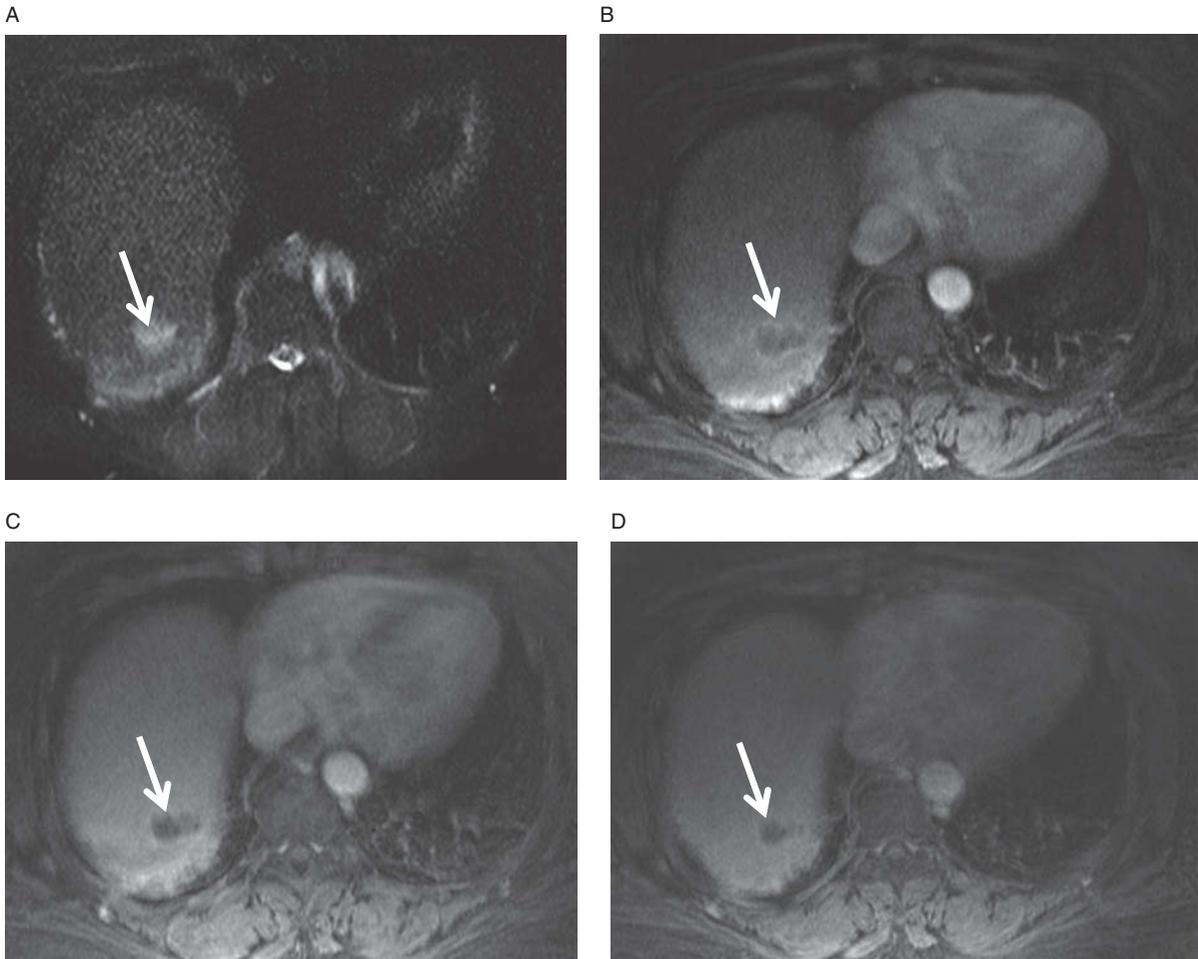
Is this a hemangioma? Axial fat-suppressed, T2-weighted images demonstrate a bright liver lesion (A). Axial, T1-weighted, fat-saturated arterial-phase image (B) demonstrates peripheral enhancement which appears to progressively fill in on delayed images (C, D). This is *not* a hemangioma. The arterial phase enhancement is not nodular or discontinuous, it is a complete ring. This is a biopsy-proven hepatocellular carcinoma (HCC). (See arrows).
